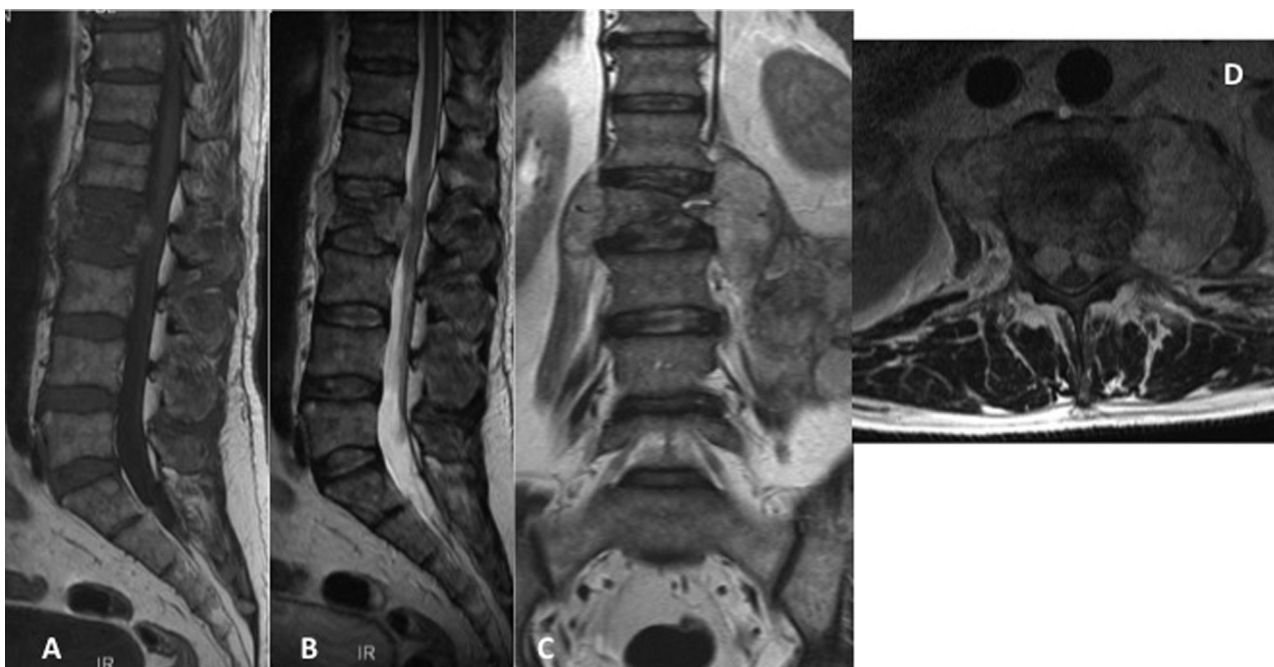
MRI of the lumbar spine.
